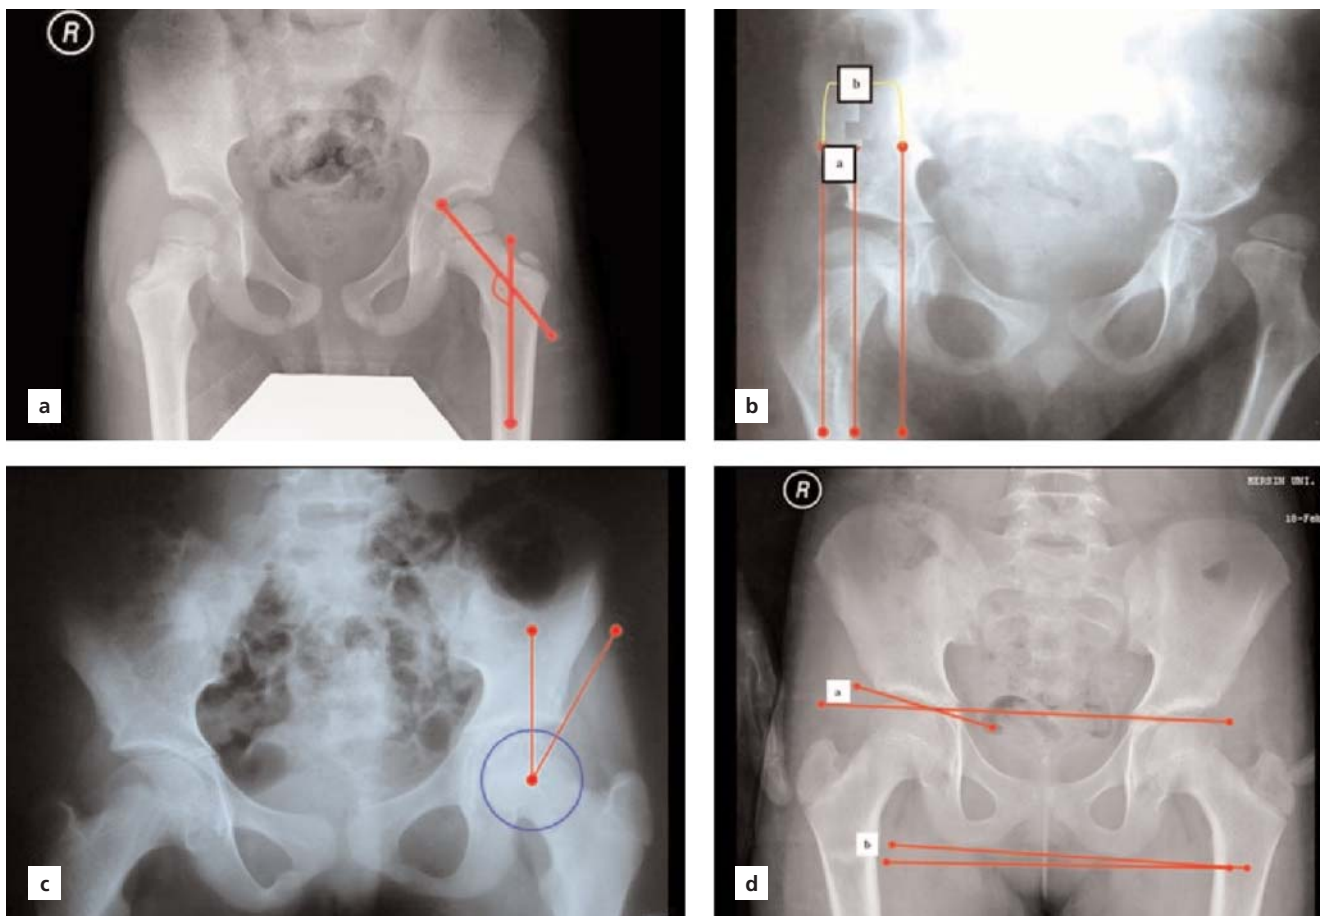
(a-d) The antero-posterior radiographics showing certain hip parameters. (a) Acetabular index diaphyseal angle (CCD). (b) Migration index (MI)=(a/b)x100. (c) Center edge angle (CEA). (d) Acetabular index (AI). a: acetabular index; b: pelvic obliquity (PO).
